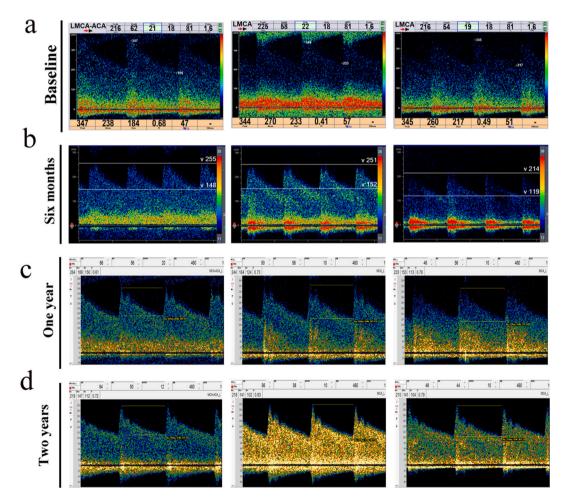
Changes in the TCD spectrum image of left MCA. (a) TCD spectrum image of left MCA at baseline. It indicated eddy formation and accelerated segmental blood flow in the left MCA. (b) TCD spectrum image of left MCA at one-year follow up. Doppler spectrum of left MCA improved and eddy also reduced. (c) TCD spectrum image of left MCA at two-year follow up. The eddy was disappeared.
